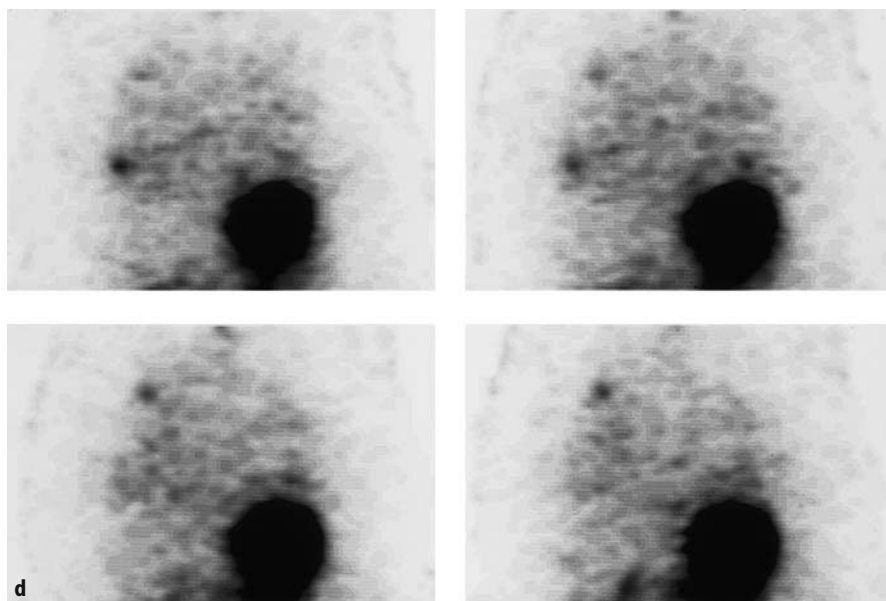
d. SPECT showed iodine-avid lung metastases
